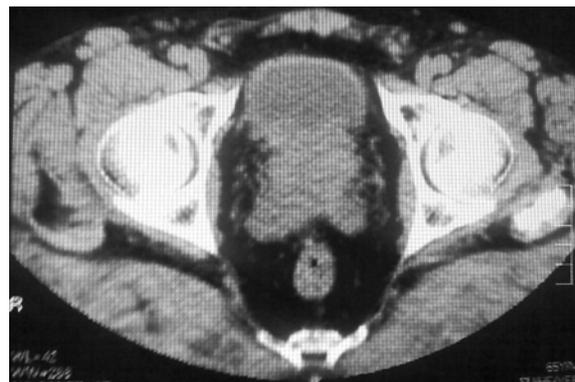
Unenhanced axial CT showing prostatic enlargement.
